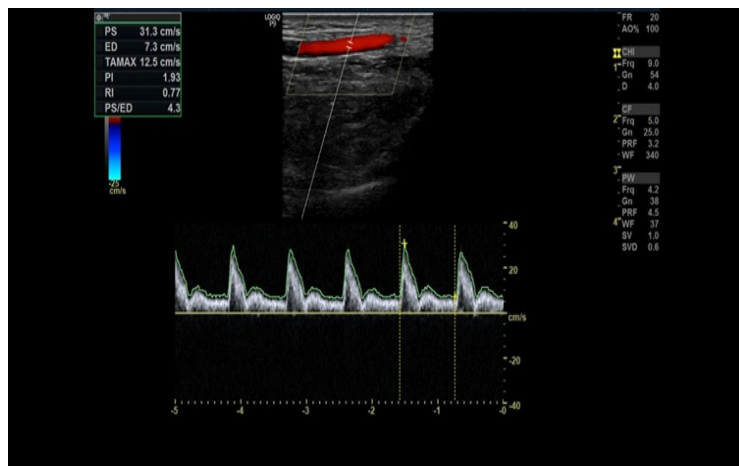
Color Doppler showing normal waveform and flow velocities in the radial artery.
